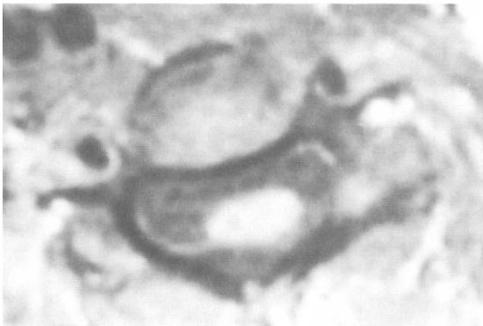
Case 1. T1-weighted sagittal (a) and axial at C6 (b) MRIs showing atrophy of the cervical spinal cord with enlarged subarachnoid space. *Intumescentia cervicalis* is not observed.
